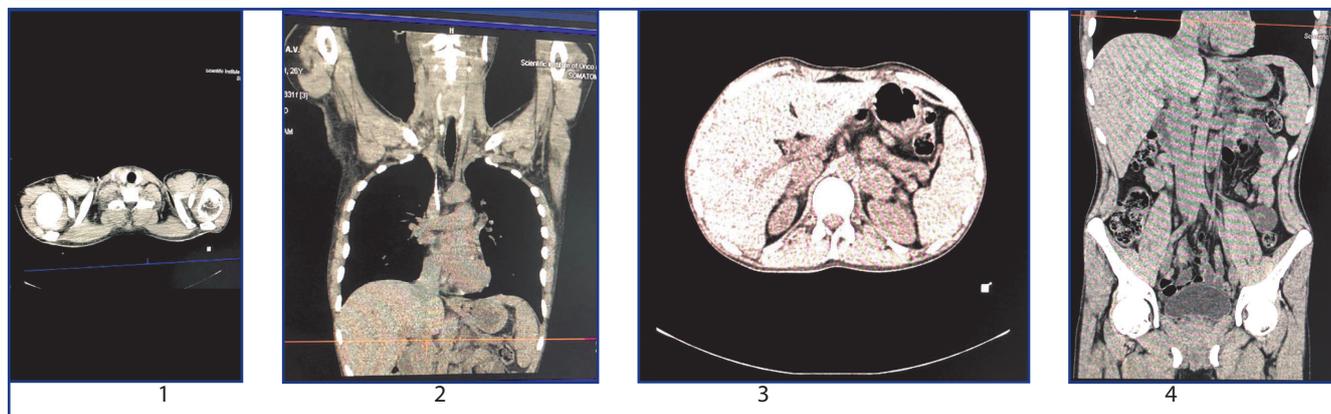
Multi-layer spiral CT after treatment. Patient M., 56 y.o.
